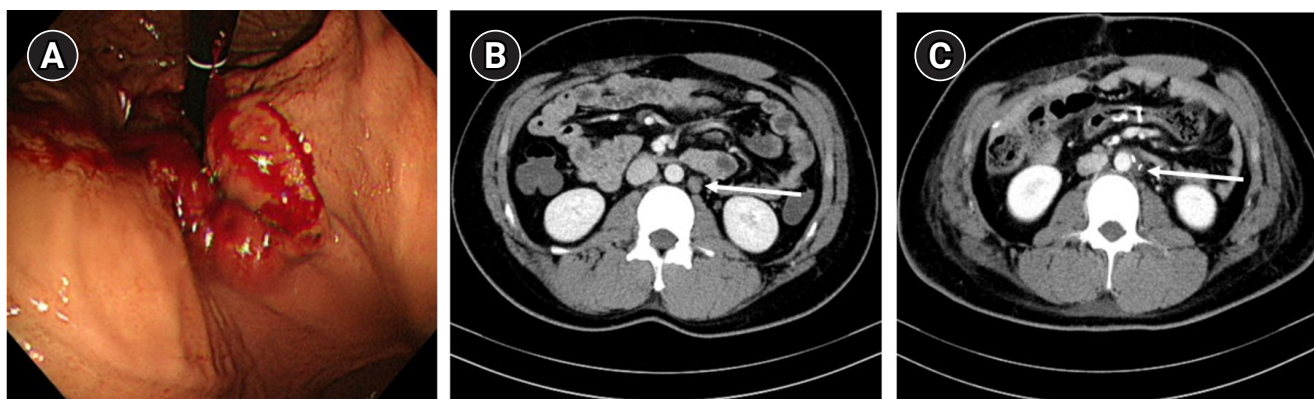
(A) Esophagogastroduodenoscopy diagnosed with gastroesophageal junction cancer. (B) Computed tomography performed 4 months after the start of neoadjuvant chemotherapy. Left paraaortic lymph node enlargement still remained (arrow). (C) Follow up computed tomography examined 4 months after the operation. The enlarged left paraaortic lymph node before the operation was resected and disappeared (arrow).
